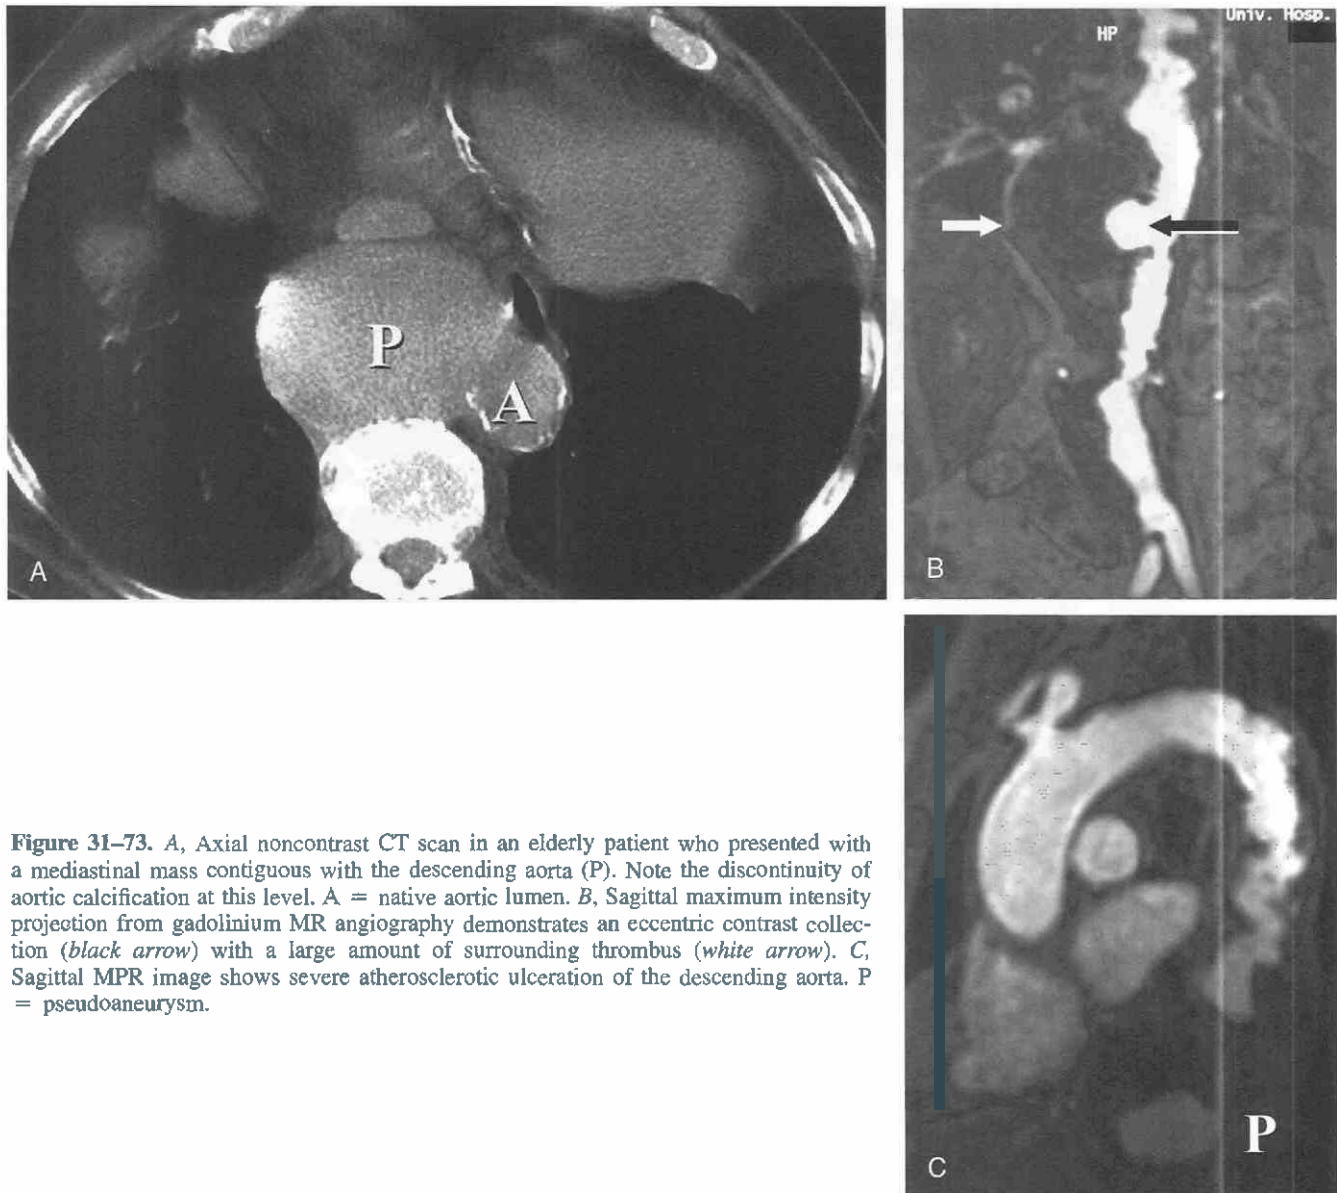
A, Axial noncontrast CT scan in an elderly patient who presented with a mediastinal mass contiguous with the descending aorta (P). Note the discontinuity of aortic calcification at this level. A = native aortic lumen. B, Sagittal maximum intensity projection from gadolinium MR angiography demonstrates an eccentric contrast collection (*black arrow*) with a large amount of surrounding thrombus (*white arrow*). C, Sagittal MPR image shows severe atherosclerotic ulceration of the descending aorta. P = pseudoaneurysm.
